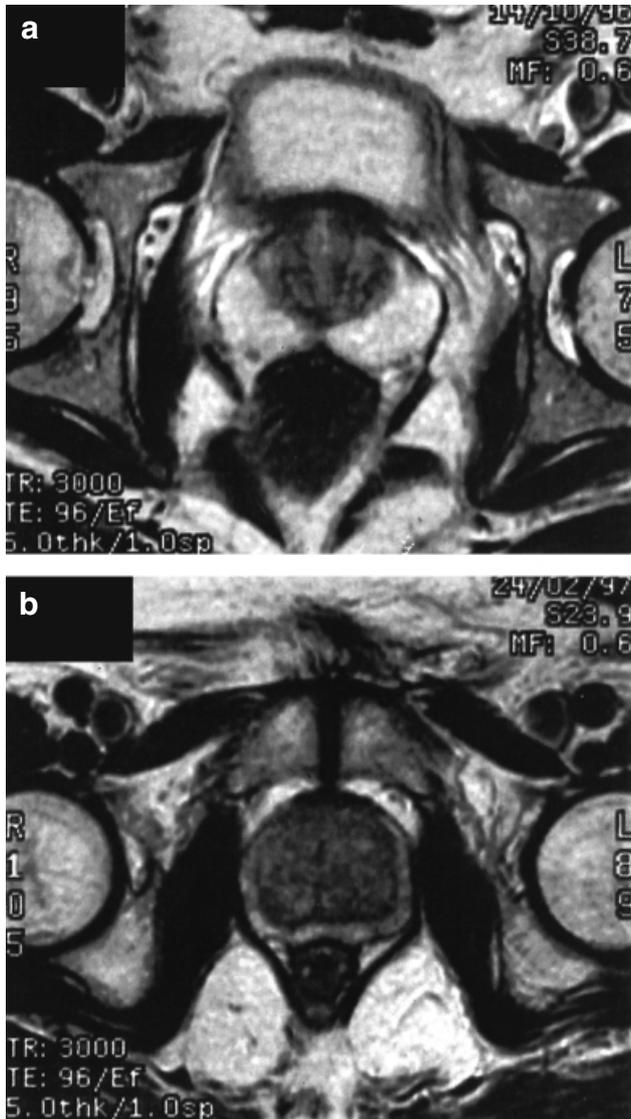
T2-weighted axial magnetic resonance image of a patient with (a) stromal hyperplasia (percent epithelium of inner gland, 5%; ratio of signal intensity of the inner gland to the obturator internus muscle, 4.32); and (b) non-stromal hyperplasia (percent epithelium of inner gland, 20%; ratio of signal intensity of the inner gland to the obturator internus muscle, 6.02).
